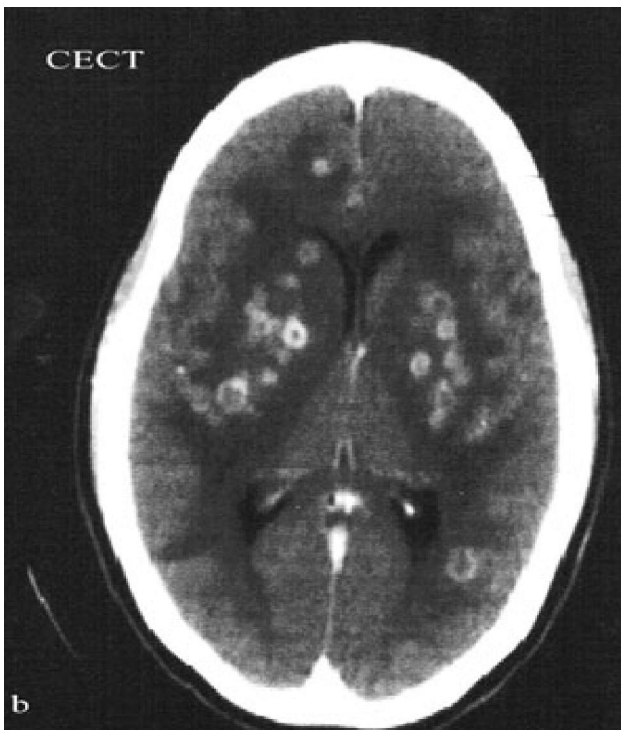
(a): Non contrast and (b) contrast enhanced CT Brain axial views showing multiple small ring enhancing lesions with significant perilesional edema.
